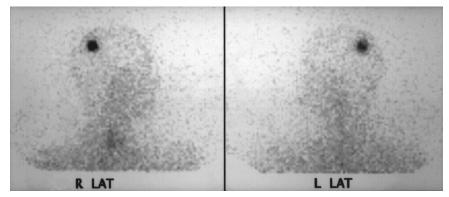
¹¹¹In-DOTATOC scintigram of 43-y-old woman with neuroendocrine cerebral metastasis of EPT before DOTATOC treatment. LAT = lateral.
